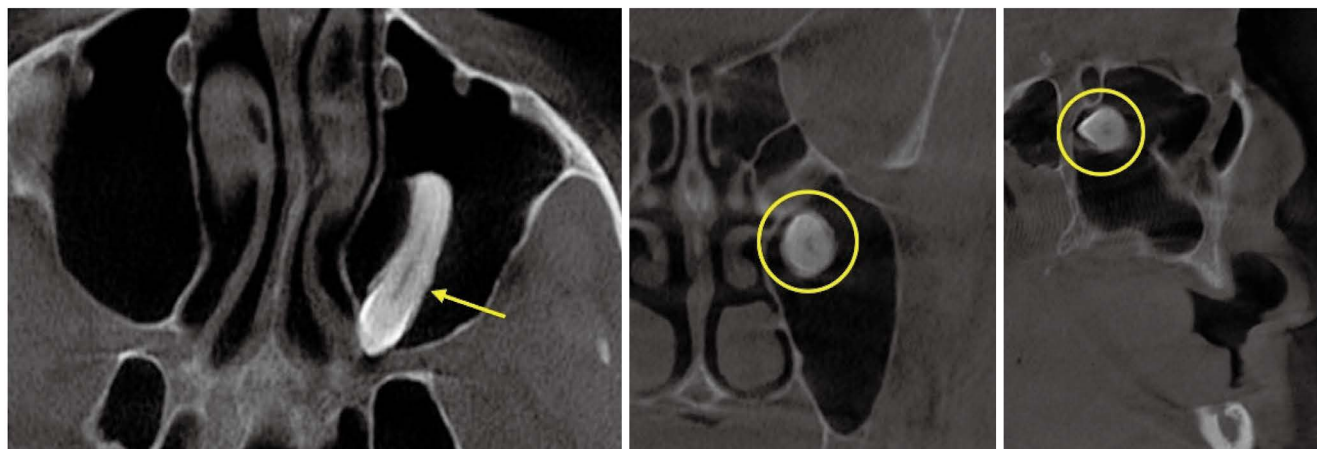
Axial, coronal, and sagittal cone-beam computed tomographic images demonstrate an ectopic tooth in the superior portion of the left maxillary sinus.
